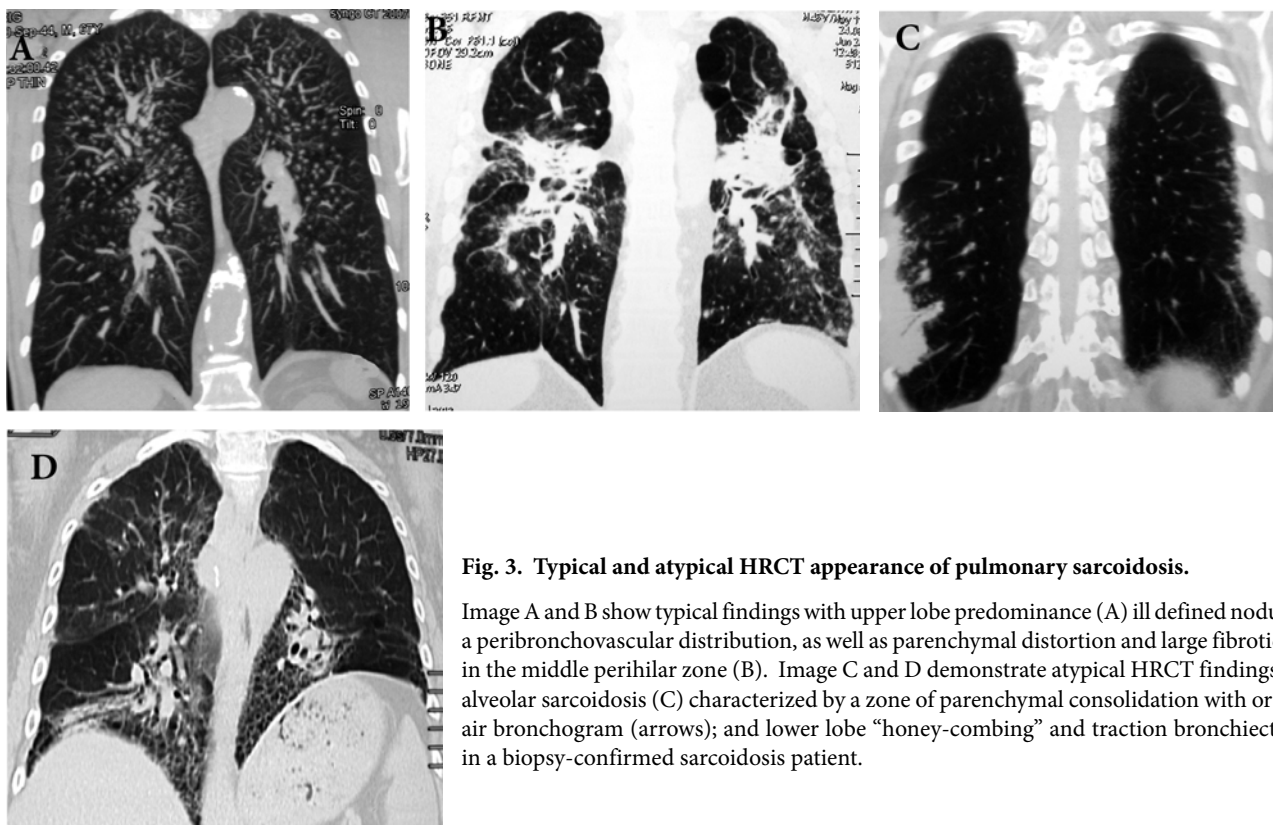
Typical and atypical HRCT appearance of pulmonary sarcoidosis.
